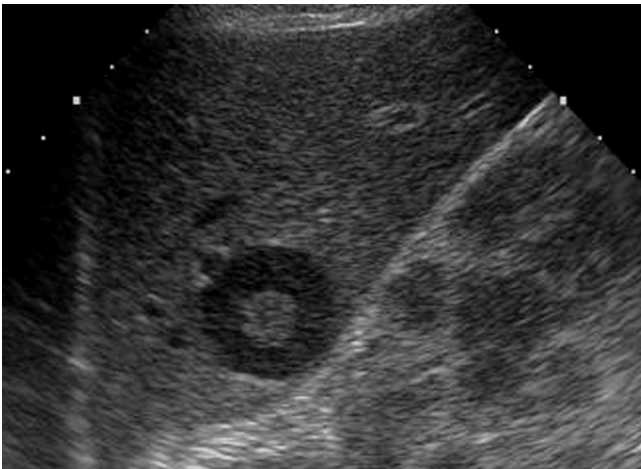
Gray scale sonographic image through the liver demonstrates a round hepatic lesion with isoechoic center and hypoechoic rim.
